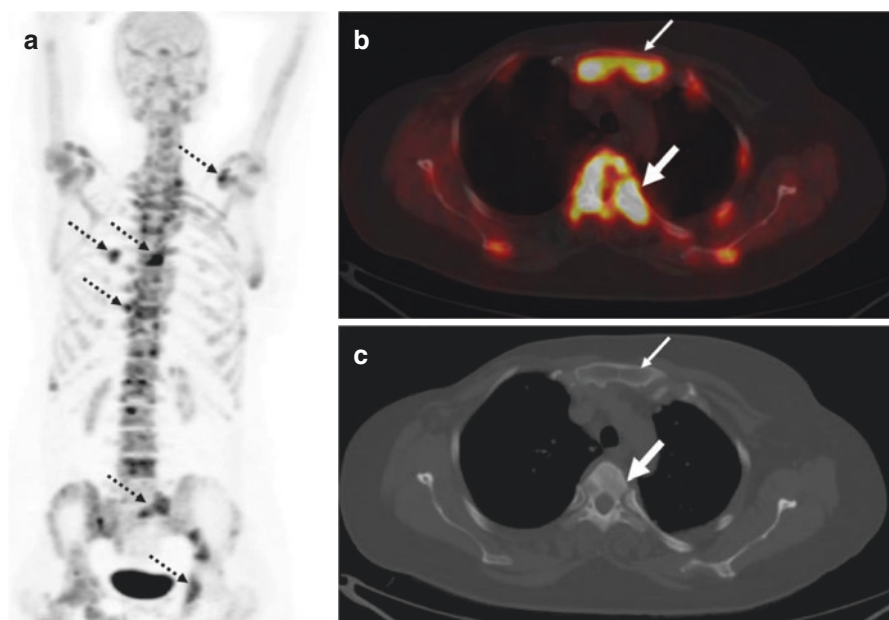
A 53 year-old-woman with carcinoma breast underwent ^{18}F -Sodium Fluoride PET/CT done as a part of initial staging. The scan showed multiple tracer avid skeletal metastases, as shown in the maximum intensity projection image (a, dotted-arrows). Representative trans-axial fused PET/CT (b) and CT (c) images show intensely tracer avid lesions in the dorsal vertebral body (thick-arrow) and sternum (thin-arrow)
